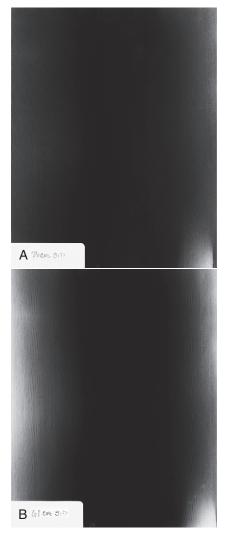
A, Radiograph taken with a 6:1 parallel grid at a source-to-image receptor distance (SID) of 76 cm. B, Radiograph taken with 6:1 parallel grid at an SID of 61 cm. Optical density decreases from the center to the edge of the image and to complete cutoff. (Courtesy Dawn Stark, Mississippi State University.)
